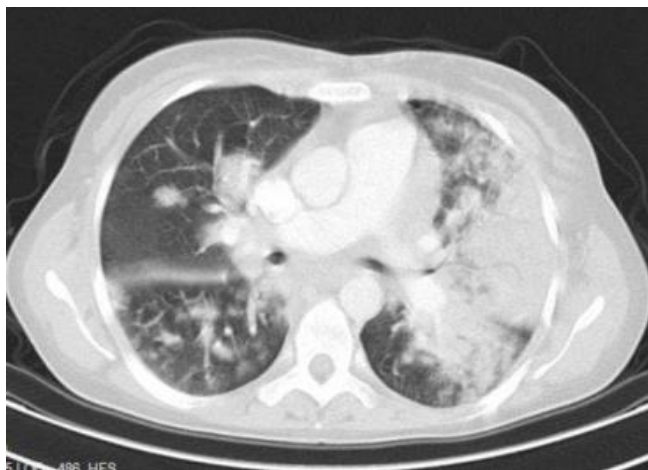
CT image of the patient.
